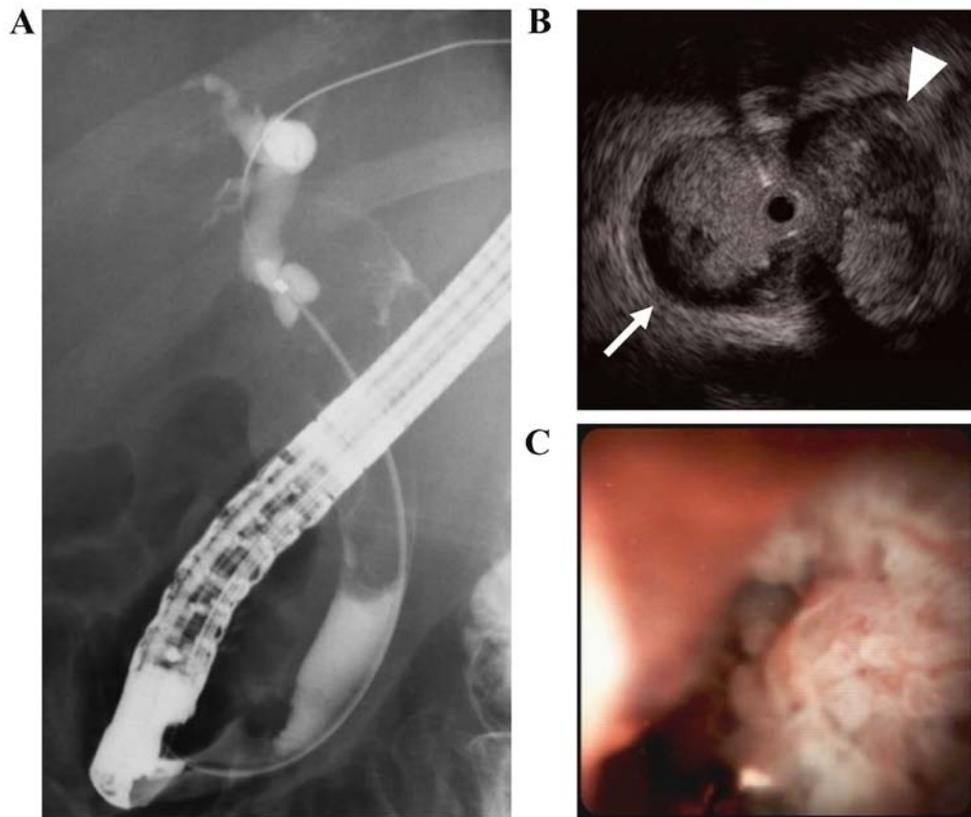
Findings of ERC, IDUS and POCS. (A) ERC showed filling defects within the common hepatic duct, but the gallbladder and cystic duct could not be visualized. (B) IDUS revealed papillary lesions protruding into the common bile duct (arrow) through the cystic duct (arrow head). (C) POCS revealed mucin-producing papillary tumors around the cystic duct orifice and extending to the lower common bile duct. ERC, endoscopic retrograde cholangiography; IDUS, intraductal ultrasound; POCS, peroral cholangioscopy.
